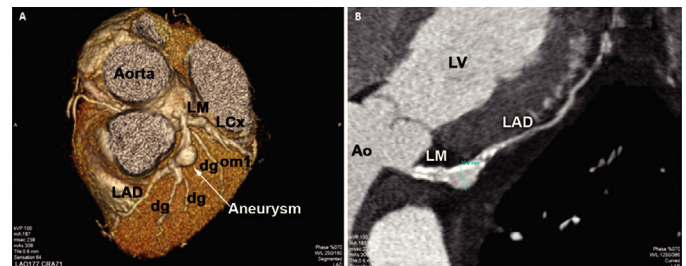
Pre-operative cardiac computed tomography showing 3D reconstruction (A) and detail of the left coronary artery (B). LM: left main; LAD: left anterior descending artery; LCx: left circumflex artery; dg: diagonal branch; om: obtuse marginal branch; LV: left ventricle; Ao: aorta.
